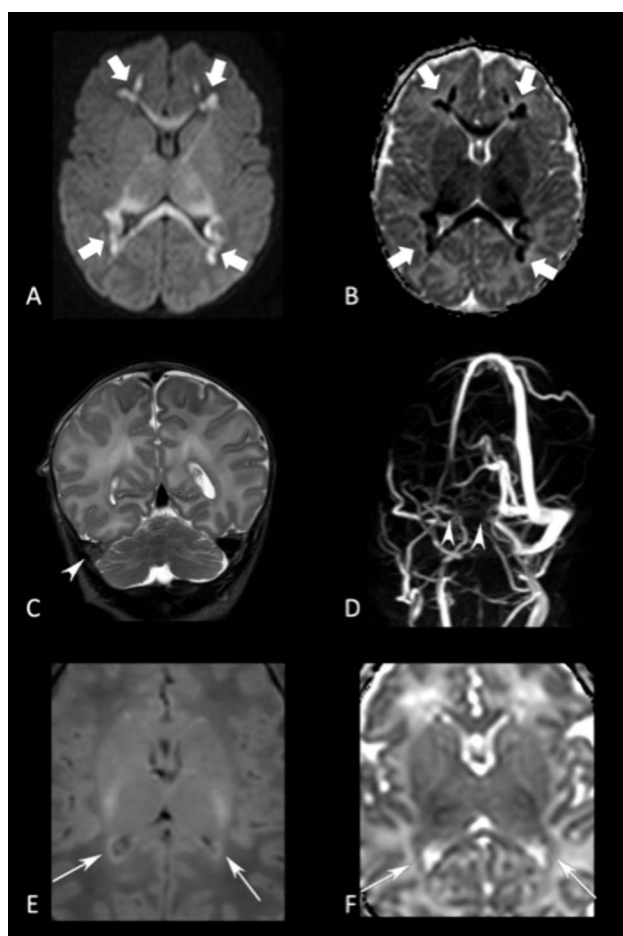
A Axial diffusion-weighted MRI of the brain (repetition time ms/echo time ms, 8500/100; flip angle, 90°; b -value = 1000 s/mm^2) and B corresponding axial apparent diffusion coefficient map (8500/100; flip angle, 90°; b -value = 1000 s/mm^2) showing areas of restricted diffusion involving the bilateral supratentorial white matter (solid white arrows on all images) and corpus callosum in a newborn with Paraechovirus encephalitis. C Coronal T2-weighted image and D 3D-phase-contrast MR venography showing reduced blood flow in the right transverse sinus (white arrowheads on all images) of a neonate with Paraechovirus encephalitis. E Axial T1-weighted image and F axial apparent diffusion coefficient map (8500/100; flip angle, 90°; b -value = 1000 s/mm^2) showing T1 hyperintensity and mild restriction of diffusion of the ependymal wall of lateral ventricles (thin white arrows on all images) in a neonate with Enterovirus encephalitis and ventriculitis
